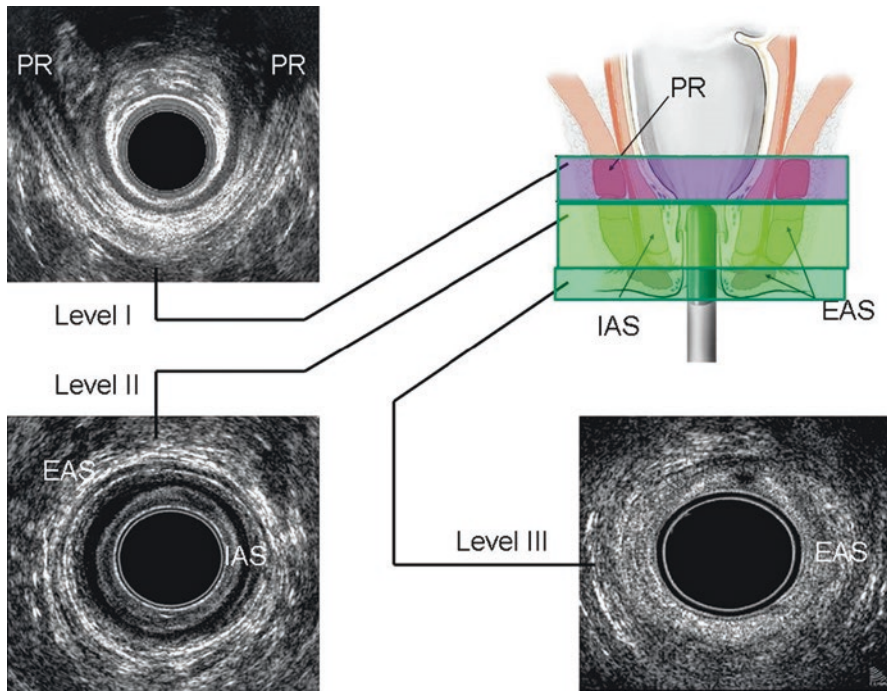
Normal ultrasonographic anatomy of the anal canal. *EAS*, external anal sphincter; *IAS*, internal anal sphincter; *PR*, puborectalis muscle
